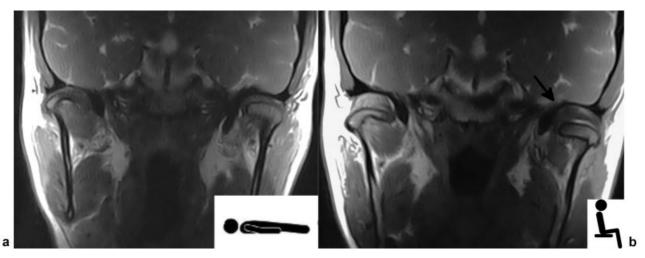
MRI coronal acquisitions of the temporomandibular joint with the mouth closed. (a) The supine examination shows a good left articular congruence. (b) Weight-bearing scan of the same patient shows mesial displacement (arrow) of the articular disk.
